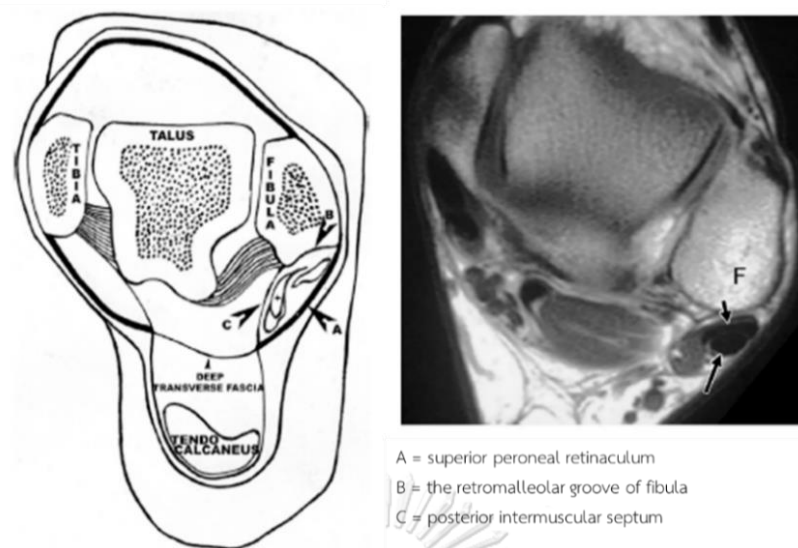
5 The cross sectional structure and T-1 MR imaging of the superior peroneal tunnel (modified from Wang (2005) and Athavale (2011))^(12, 18)
